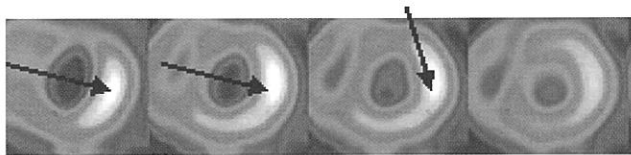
¹⁸F-FDG metabolism images
